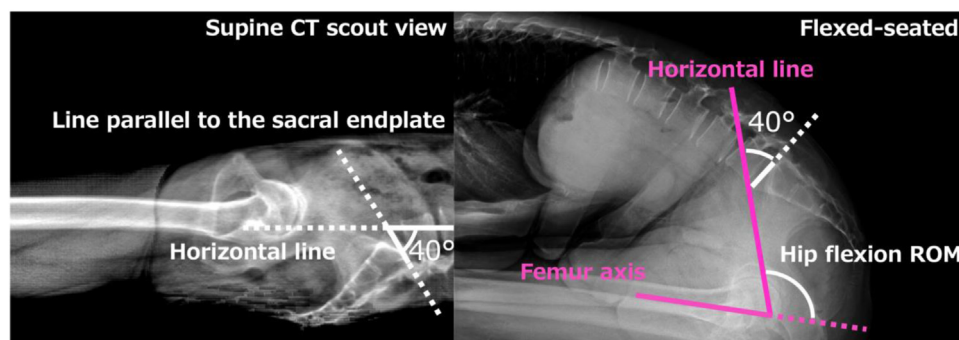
Assessment method for radiographic hip flexion ROM. ROM, range of motion.
